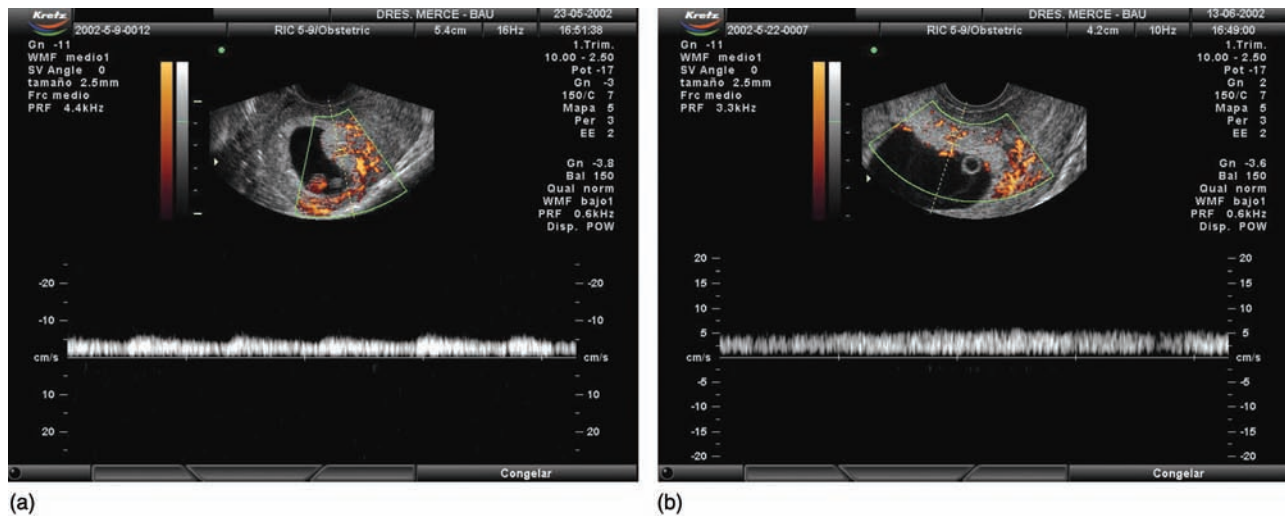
Doppler signal from the intervillosal circulation of arterial type (a) in the seventh week and venous type (b) in the ninth week.
